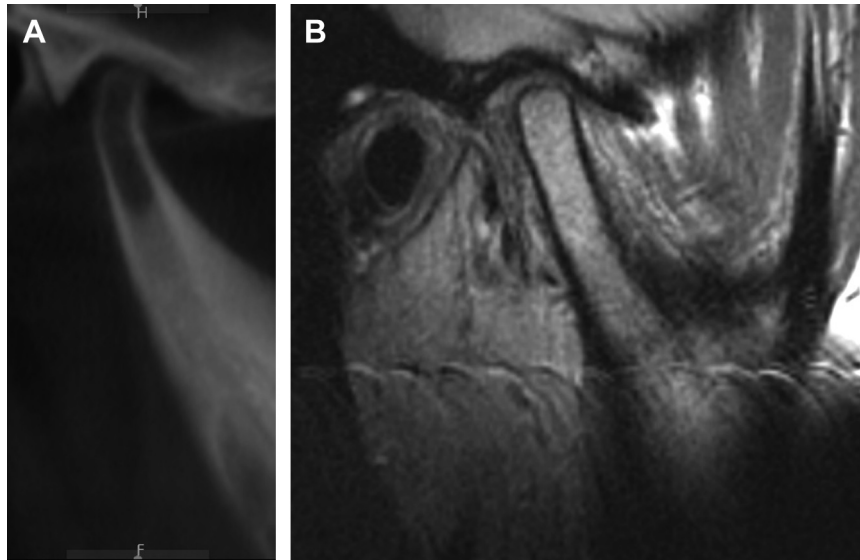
(A) At CT scan, the CH type 1 shows an increased vertical length of the condylar head and neck. (B) At the MRI, the CH type 1 shows a thin disc that is difficult to identify, and can be posteriorly displaced.
